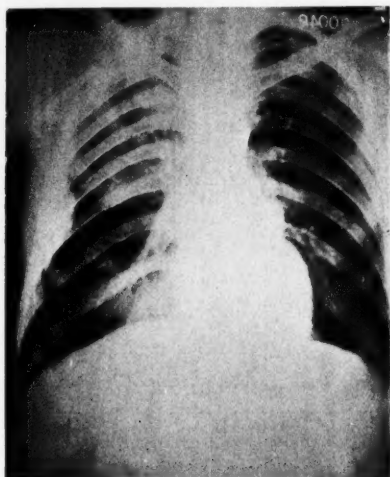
Roentgenogram, Case 2, showing abscess of right lateral chest wall and fibrosis at the right base.
